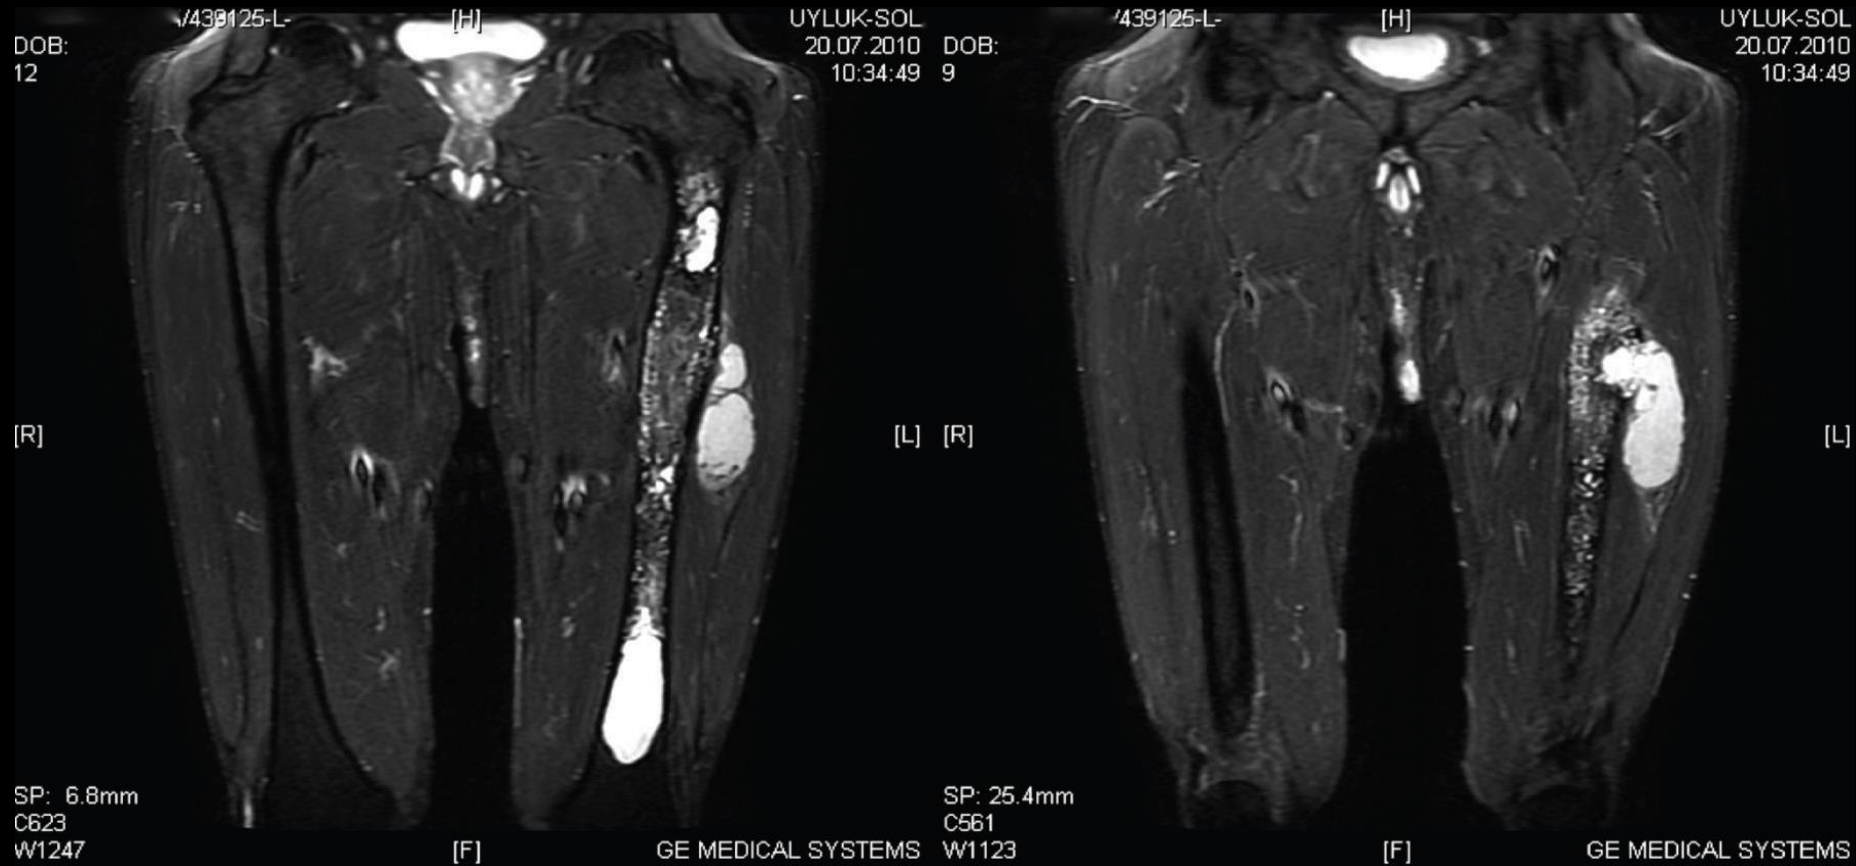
T2-weighted MRI views showing the bony involvement and the soft tissue extent.
